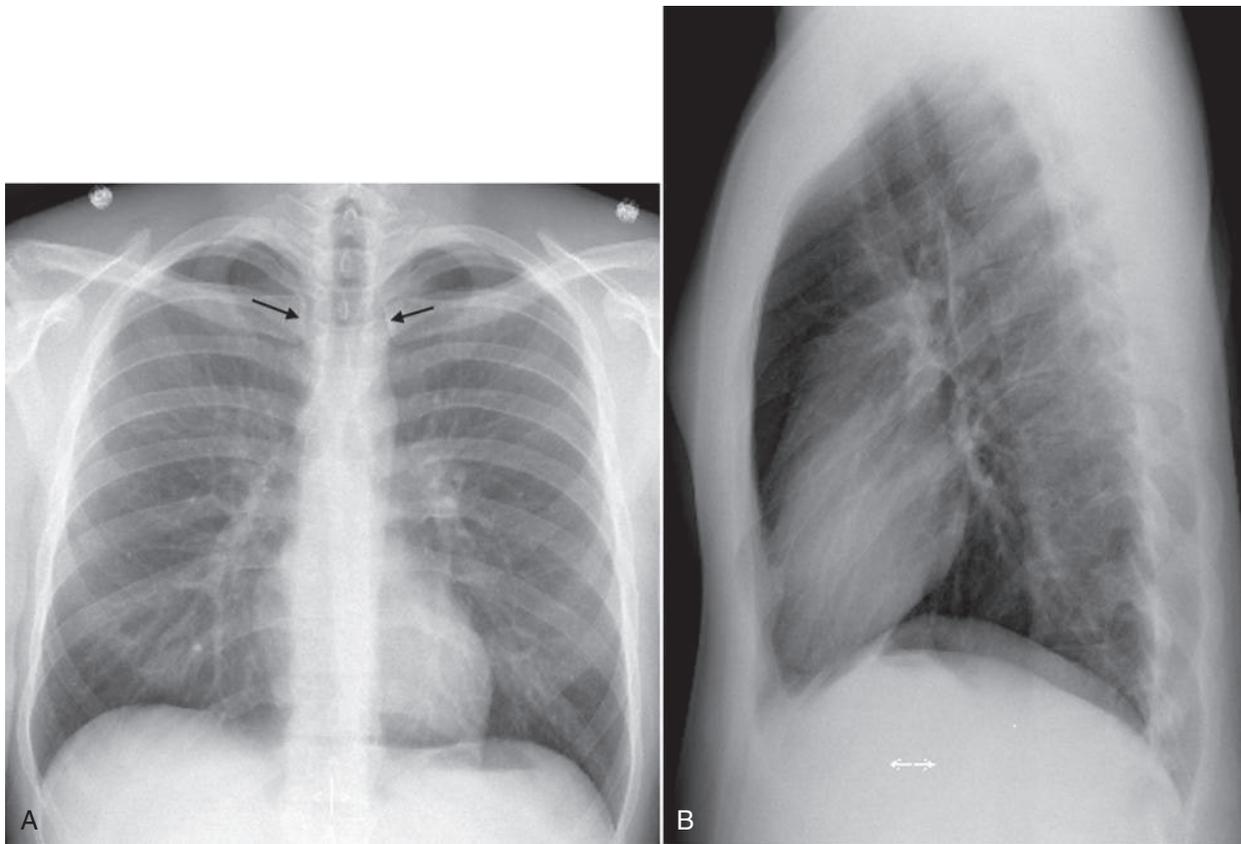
Normal frontal (A) and lateral (B) views of the chest radiograph. Note the medial ends of the clavicles (arrows) with the spinous process (arrowhead) framed between them (A).
